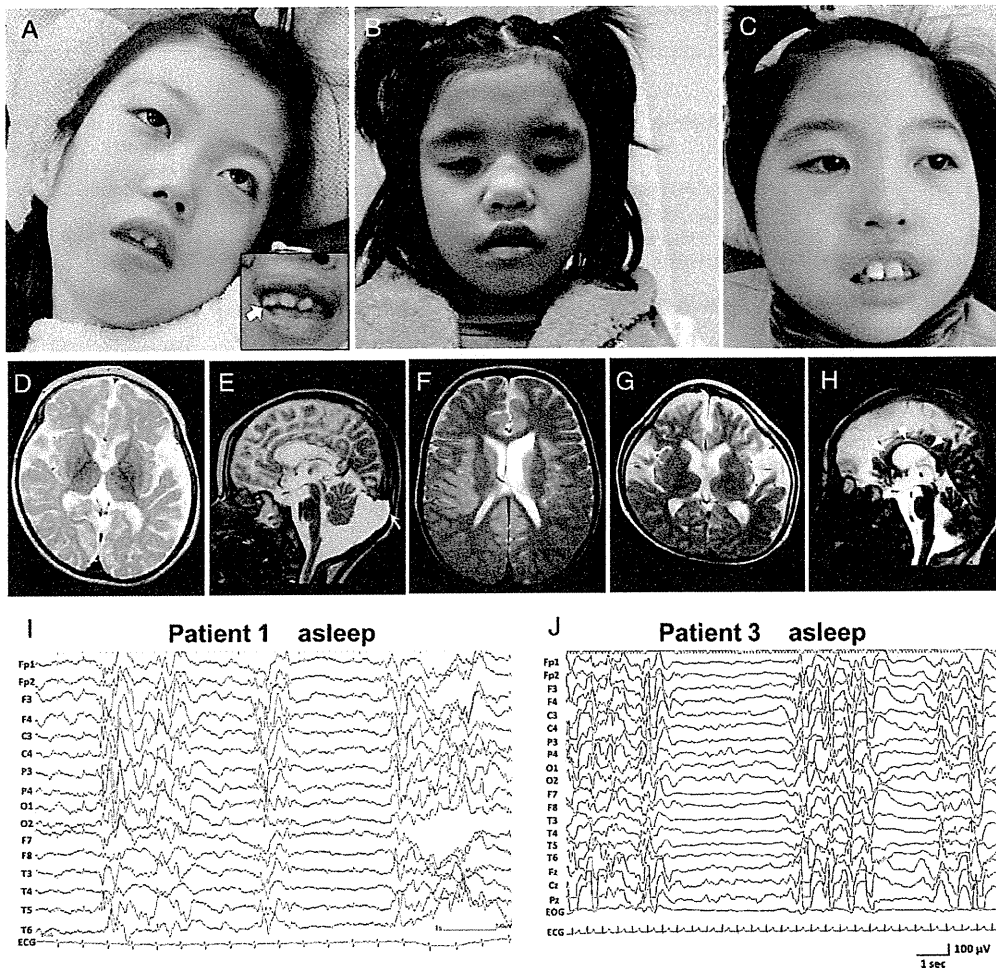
Facial appearance, brain (MRI), and EEG of the three patients with a *SLC35A2* mutation. A–C: Photograph of patient 1 at 8 years of age (A), patient 2 at 12 years of age (B), and patient 3 at 10 years of age (C). Note the broad nasal bridge, thick eyebrows, thick lips, semi-open mouth, and maxillary prognathism that are common in these three patients. A fused tooth observed in patient 1 is indicated by an arrow (A, inset). D and E: T2-weighted MRI of patient 1 at 2 years and 4 months after corpus callosotomy showed cerebral atrophy on an axial image (D), and cerebellar atrophy and an arachnoid pouch (white arrow) on a sagittal image (E). F: A T2-weighted axial image of patient 2 at 4 years and 3 months showed slight enlargement of the left lateral ventricle. G and H: T2-weighted MRI of patient 3 at 7 years showed cerebral atrophy with frontal lobe predominance on an axial image (G), and cerebellar atrophy and a thin corpus callosum (white arrowheads) on a sagittal image (H). I: Interictal EEG of patient 1 during sleep at 1.5 months old showing diffuse spike or sharp and slow-wave complexes, which were accompanied by brief suppression for 1–2 sec. J: Interictal EEG of patient 3 during sleep at 3 months old showing hypsarrhythmia.
